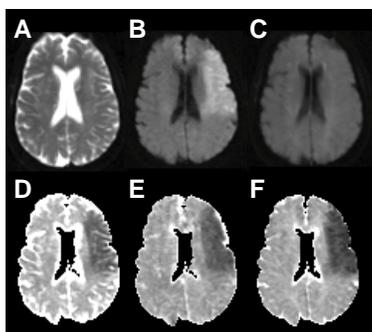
Axial slice from acute stroke patient. A) DWI b=0, B) DWI b=1000, C) FLAIR b=0, D) Conventional ADC, E) CSF suppressed ADC, and F) CSF suppressed ADC calculating by substituting the DWI b=0 image with the FLAIR image.
